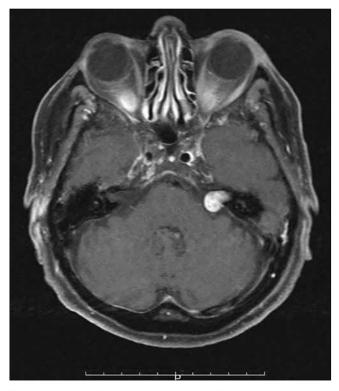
Axial T1-weighted post contrast MRI demonstrate a post contrast enhancing small acoustic neuroma in the left cerebellopontine angle.
